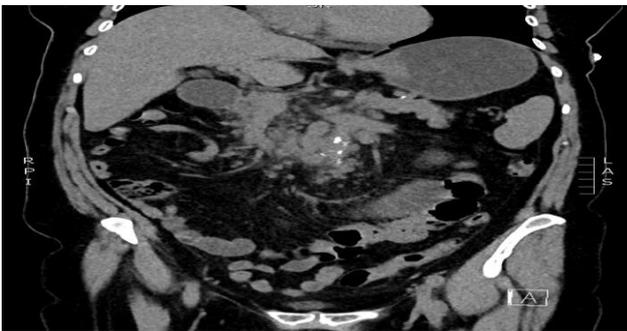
CT image of multiple enlarged lymph nodes.
